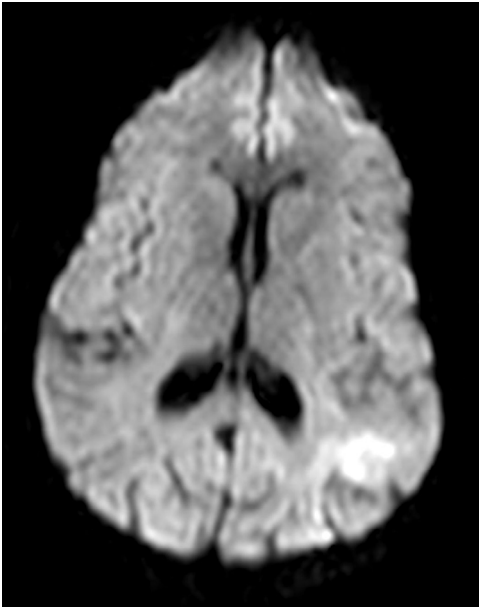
Brain magnetic resonance imaging diffusion-weighted sequence showing increased signal in the territory of the left middle cerebral artery.
